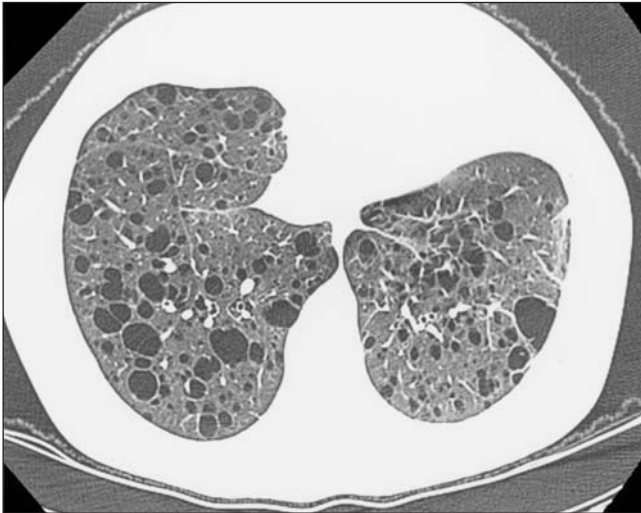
High resolution computed tomography scan slice from 1997 showing multiple thin-walled cysts typical of lymphangioliomyomatosis
